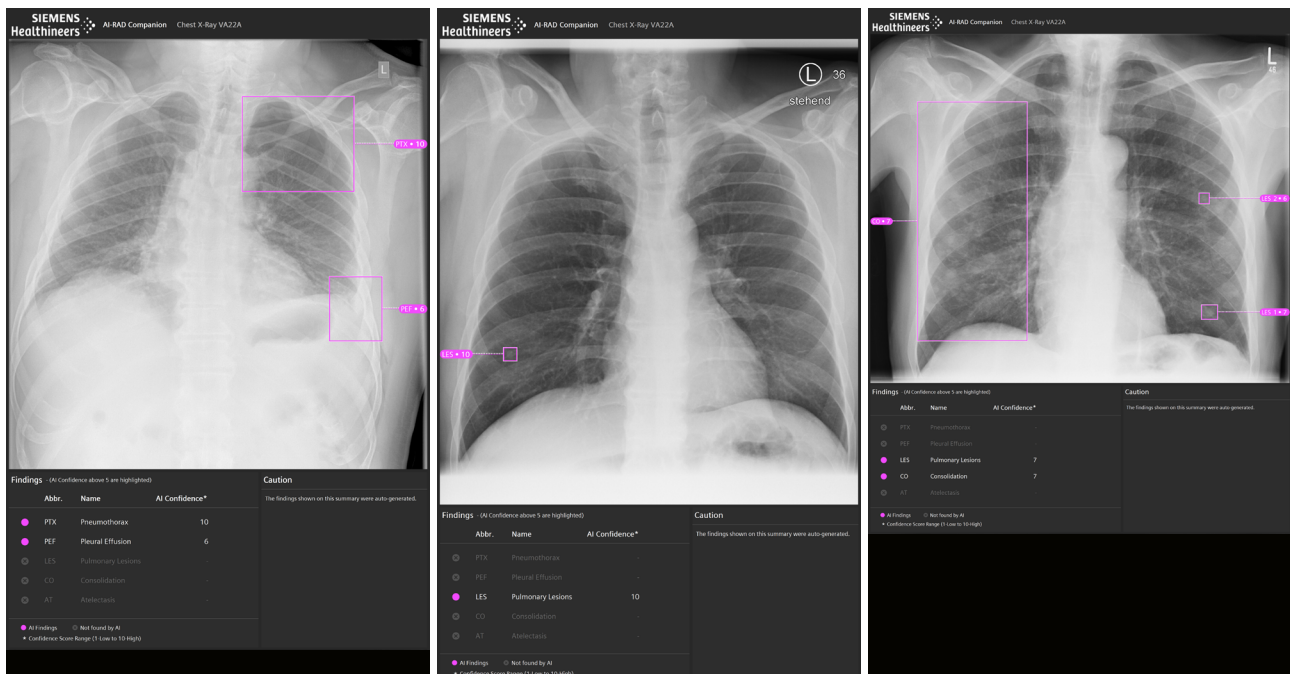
Description of elements in results generated by AI-Rad Companion Chest X-ray.
